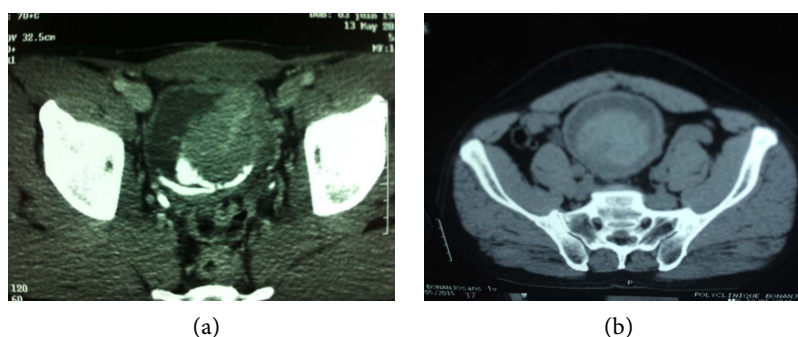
CT images of bladder tumors. (a) Muscle-invasive bladder tumor; (b) Nonmuscle-invasive bladder tumor.
